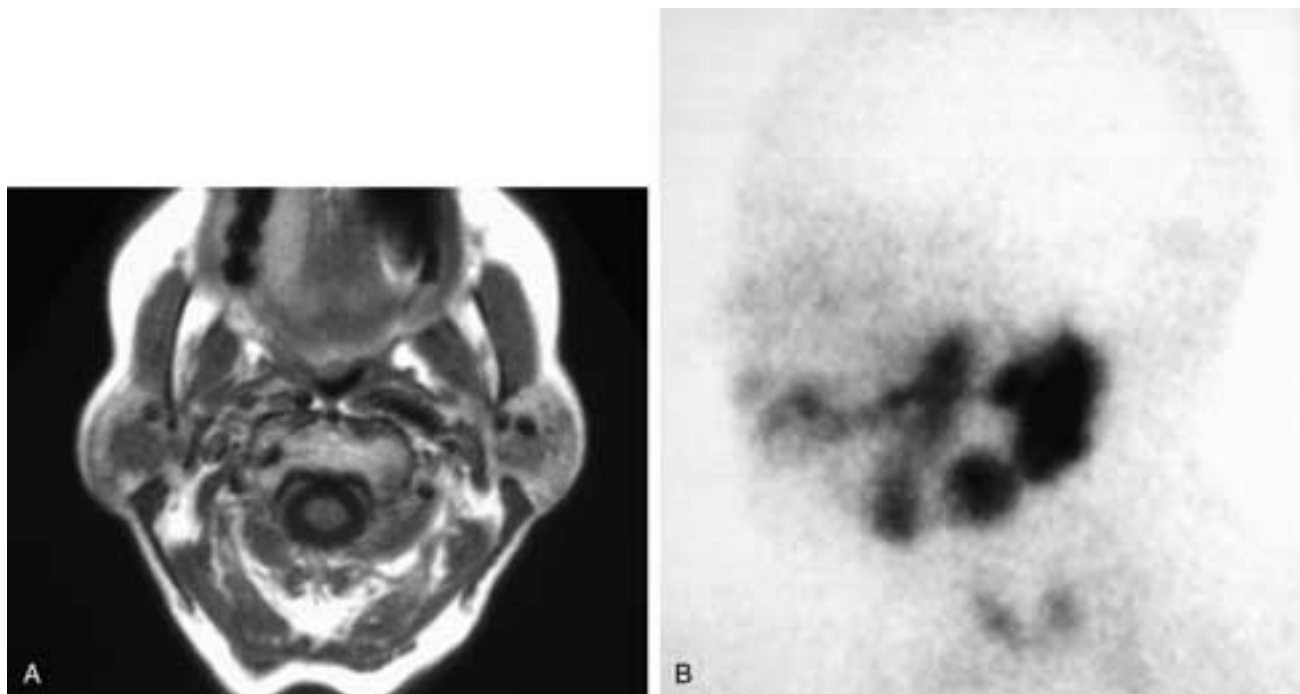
Axial T1-weighted MR image (A) shows multiple masses in each parotid gland. A left lateral ^{99m}Tc sialogram (B) shows multiple bilateral masses with intense accumulation of the nucleide. This patient had bilateral multiple oncocytomas.
